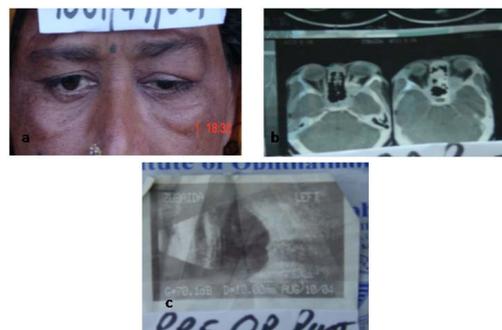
(a) Preoperative picture of meningioma of the optic nerve; (b) CT scan; (c) B scan of the orbit.
